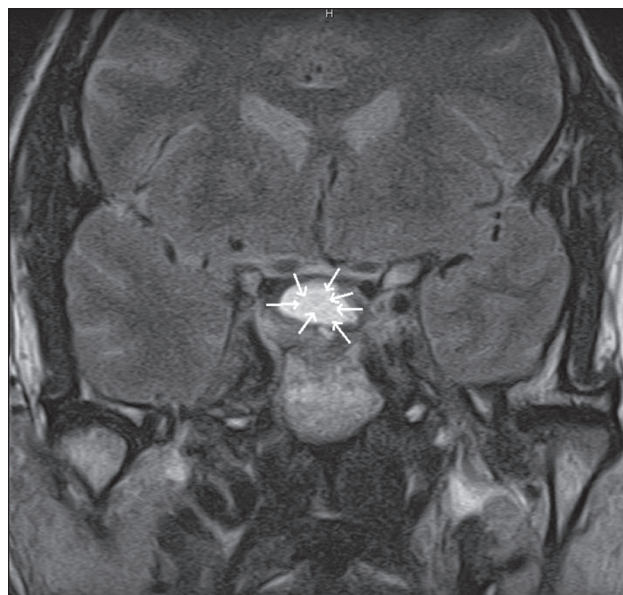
Coronal T2-weighted image of the brain showing a large complex sellar mass with heterogeneous hyperintensity suggesting hemorrhage, as indicated with arrows.
